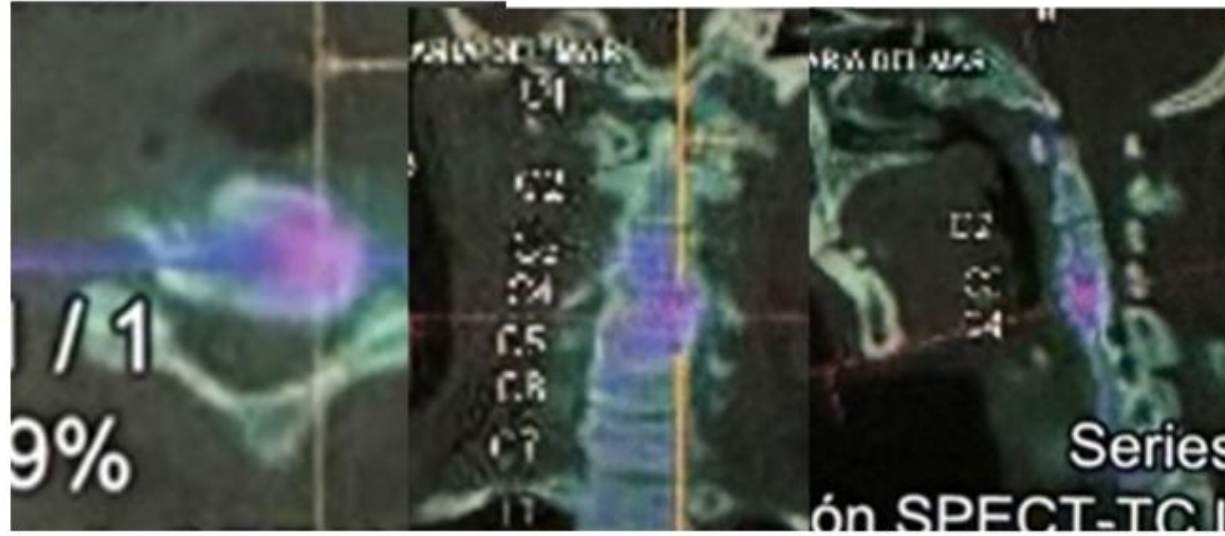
Fused axial, coronal and sagittal single photon emission CT with CT images demonstrated increased radiotracer uptake in the C4 to C5 disc. The patient was then referred for percutaneous C4-5 discoplasty with thermal radiofrequency and intradiscal injection of O2-O3 and LR-PRP, according to Vertebra Clinic protocol and technique.
